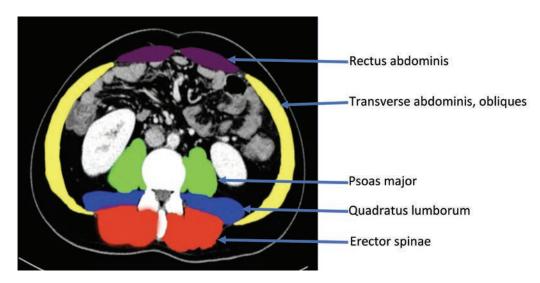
Sample image of L3 skeletal muscle index measurement on computed tomography imaging.
